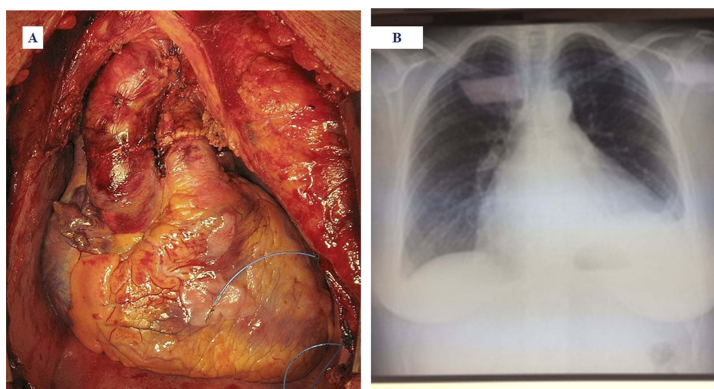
The picture shows a heart transplantation (sternotomy) with autologous pericardium (A) and our patient in position for a standard PA (posterior-anterior) chest x-ray (B).
